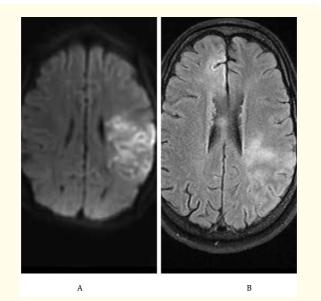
A: DWI sequence in favor of acute ischemic stroke, B: FLAIR sequence of linear cortical hypersignal area in favor of cortical SAH
